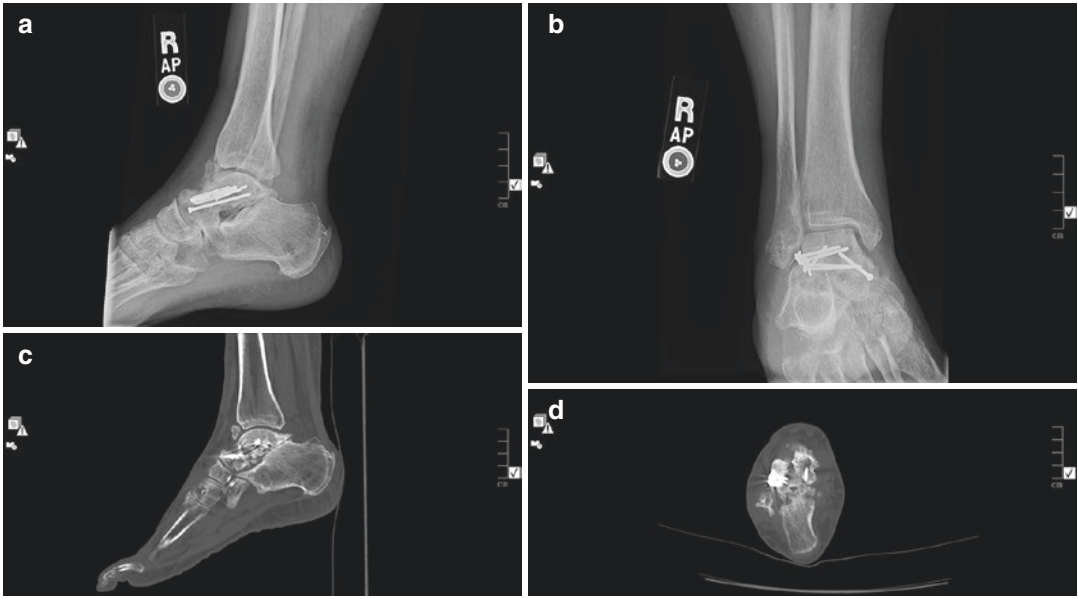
(a–d) Postoperative films at 18 months with CT confirmation demonstrating integration of ICBG structural graft (best seen on axial CT), union, maintenance of talar blood supply, and severe post-traumatic subtalar
